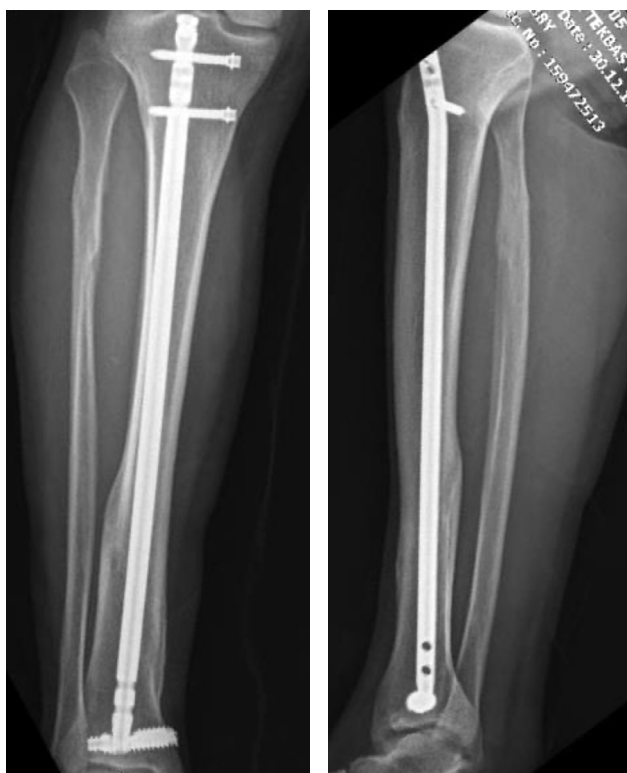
A 38-year-old male, AO type 43-C1.3 fracture treated with DBSL, at 42 weeks follow-ups AP and LAT radiographic images. The union was achieved at 12 weeks.
